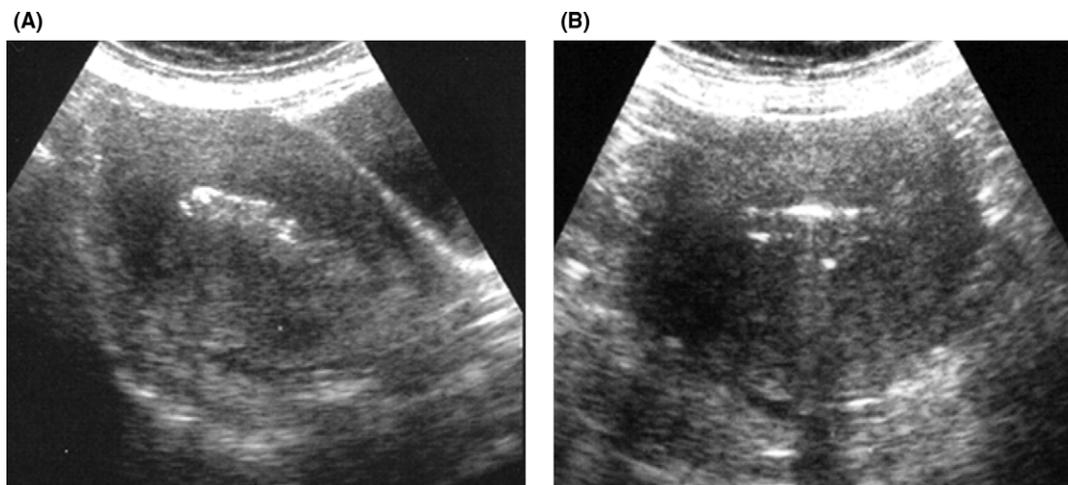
Ultrasonographic image of APC gel remaining in the uterine cavity after 24 h (A) and 72 h (B).
